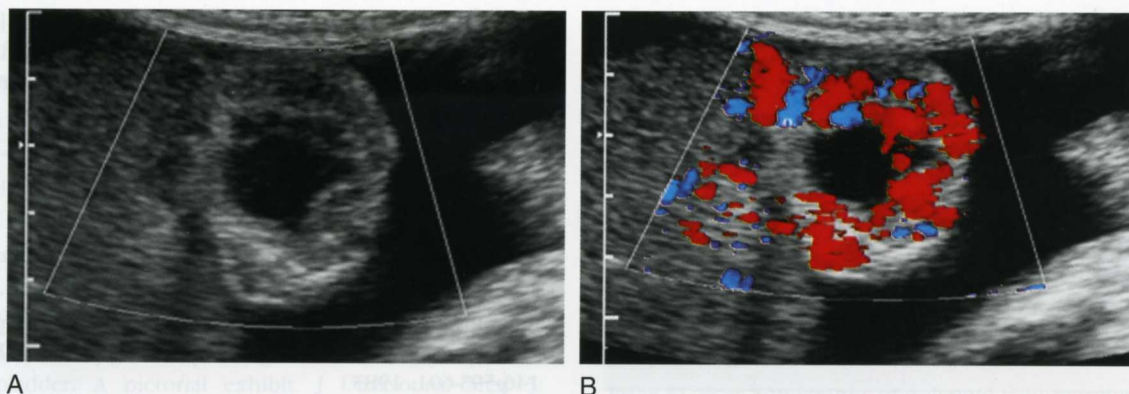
Gallbladder wall varices. Transverse gray-scale (A) and color Doppler (B) views of the gallbladder show wall thickening secondary to diffuse gallbladder wall varices.
